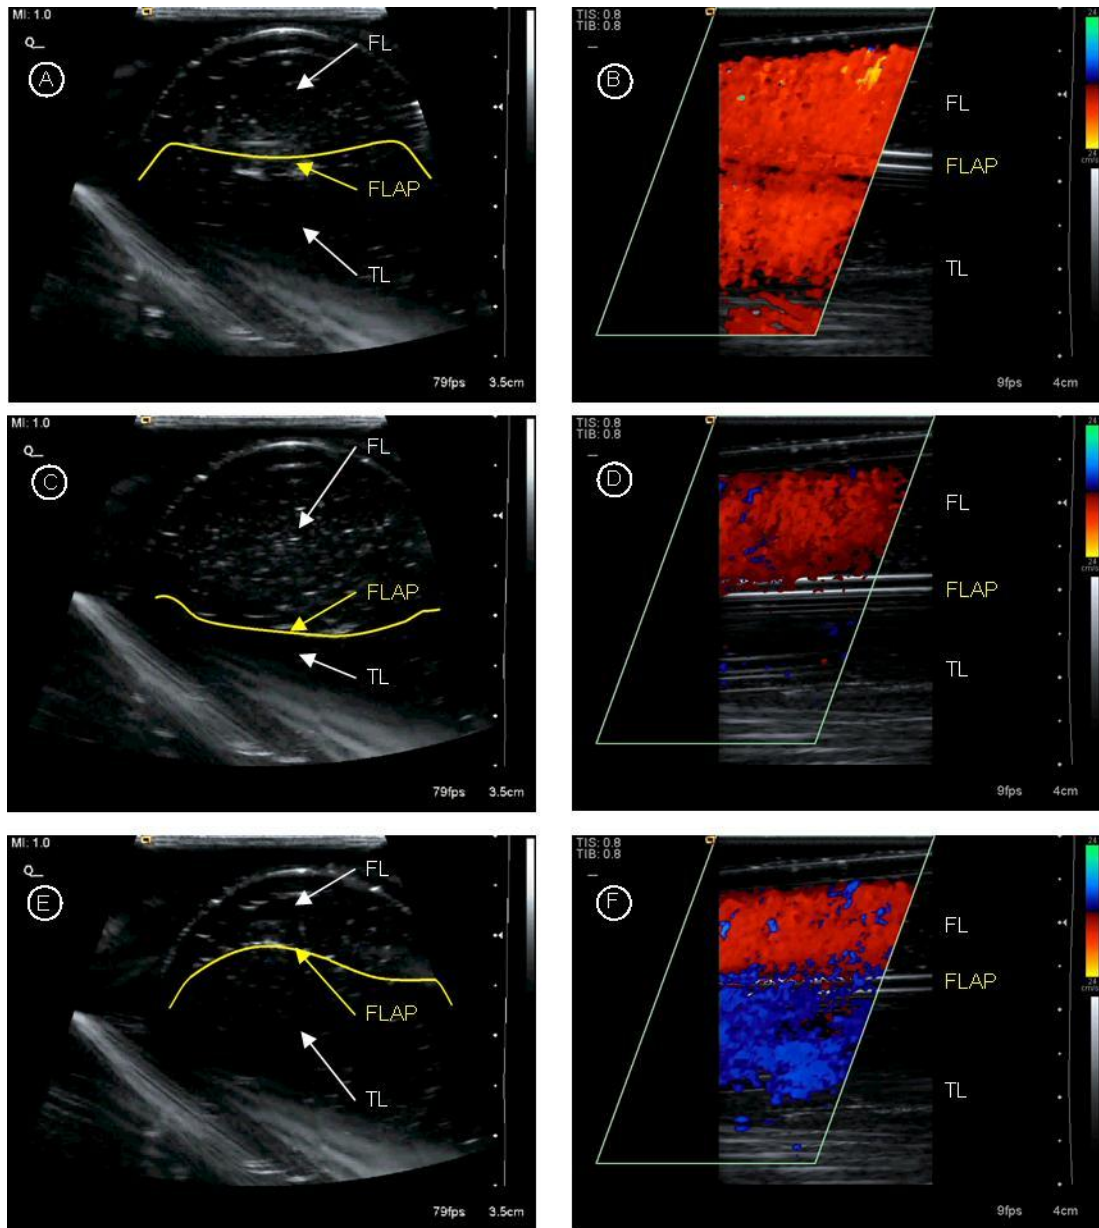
US images of acute dissection. Left column – transverse view, right column – longitudinal view with Doppler. Image A & B prior to peak systole – flow in both lumens. Image C & D just after peak systole – flow occluded in TL. Image E & F just prior to diastole – negative flow observed in TL (FL – False Lumen, TL – True Lumen)
